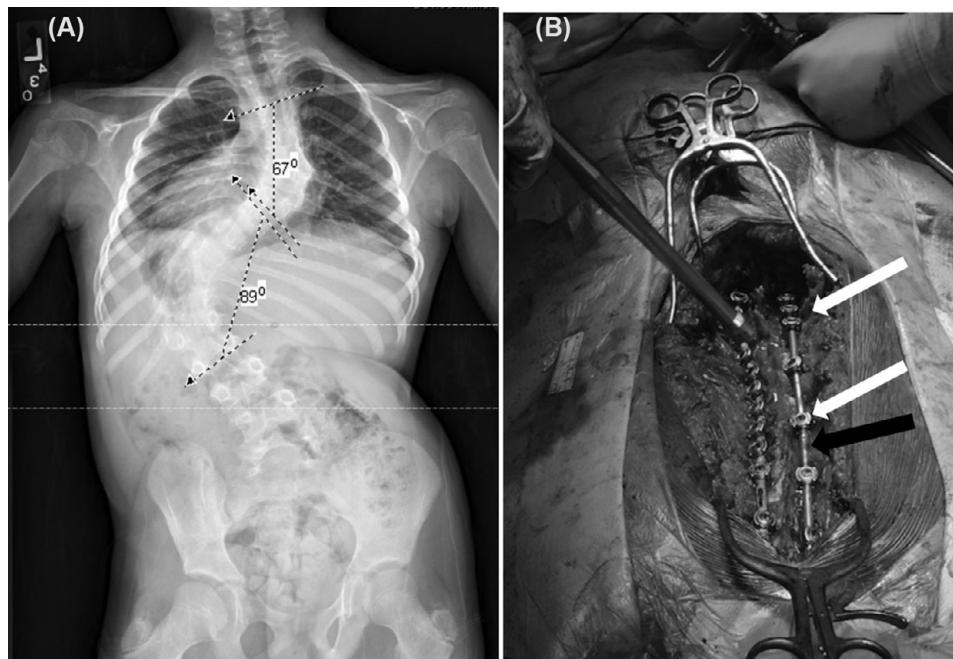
(A) Preoperative X-ray demonstrating the calculation of the Cobb angle. (B) Intraoperative image showing placement of pedicle screws (white arrows) and correction rods (black arrow) prior to curvature correction.
